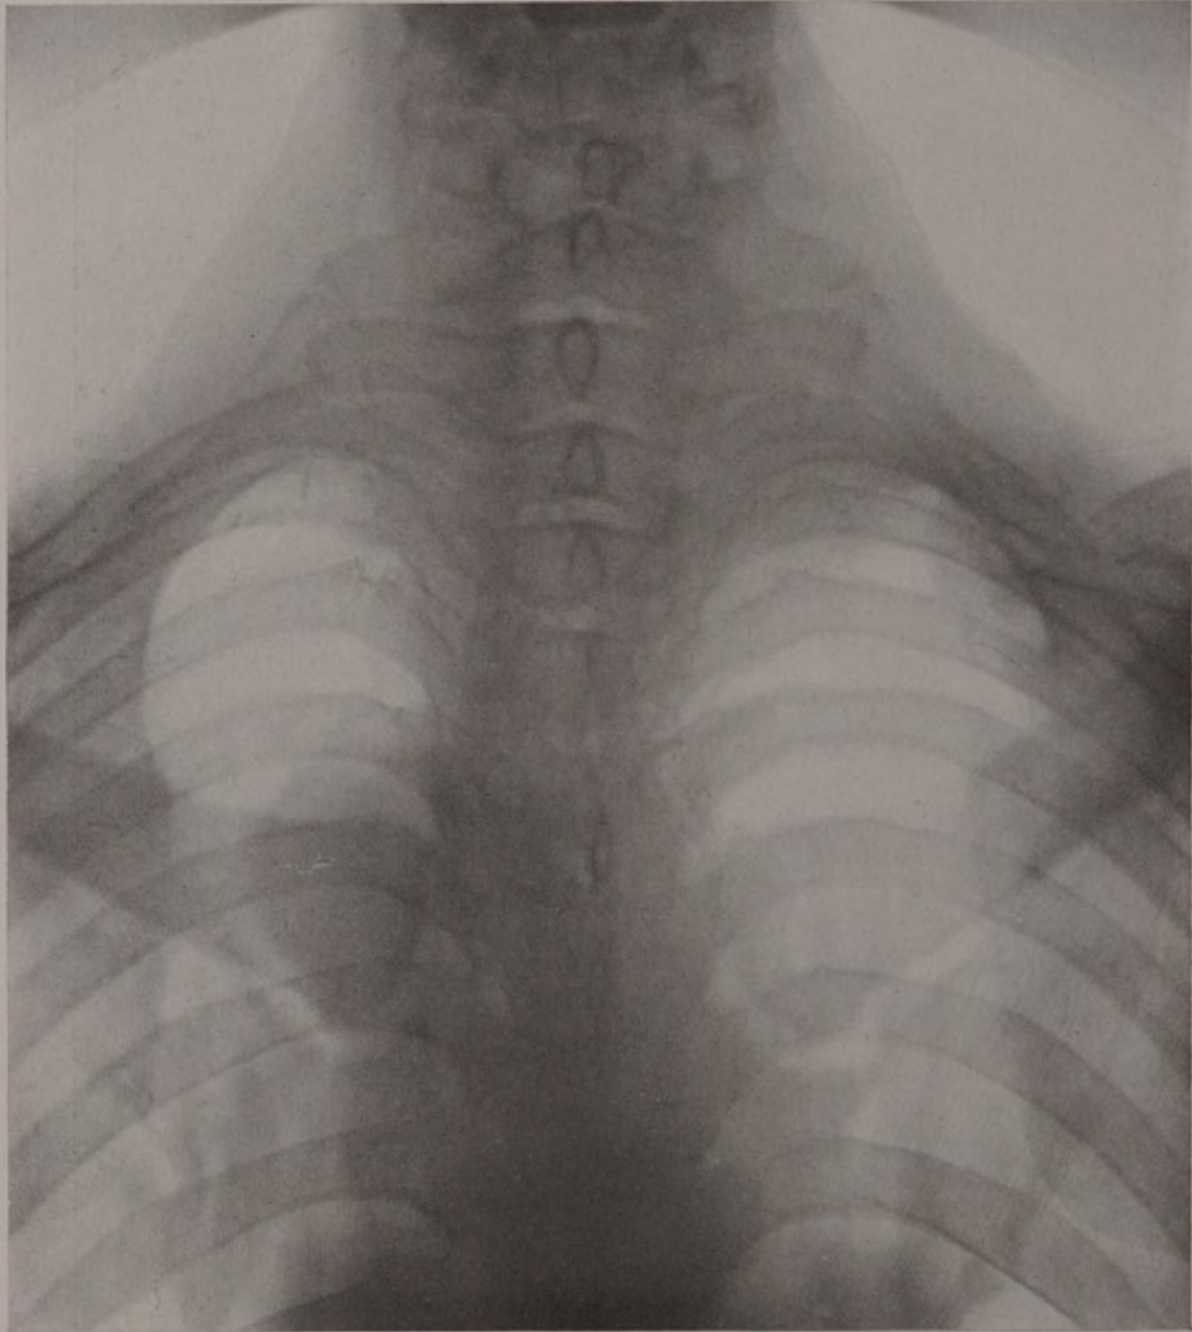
Spondylitis of the cervical and dorsal vertebræ. (From a patient with an extramedullary spinal tumor.) The X-ray findings were confusing, but did not cause the patient's symptoms.
